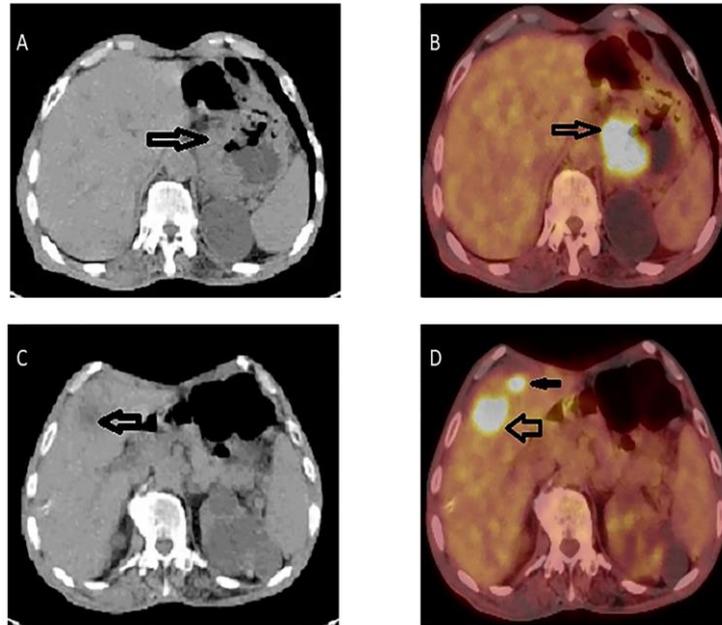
a-d. The case of adenocarcinoma located in gastric cardia region. (a) Wall thickening (arrow) is observed in axial section CT image (b) Hypermetabolic FDG involvement (arrow) is observed in primary tumor (SUVmax: 12.29) in axial section PET/CT fusion image (c) Tumor metastasis in liver is observed as hypodense area (arrow) in axial section CT image (d) Axial PET/CT fusion image shows focal hypermetabolic FDG involvement (SUVmax: 15.9) in liver metastases (arrows).
